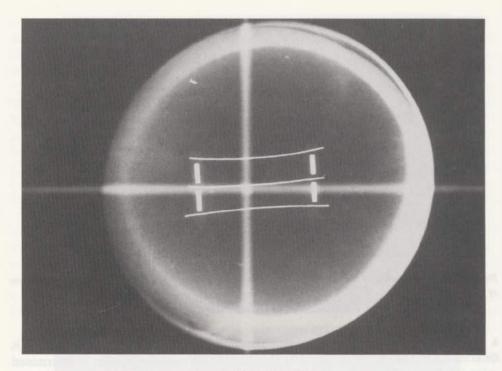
The metal nucleus in the spacers permits X-ray visualization.
